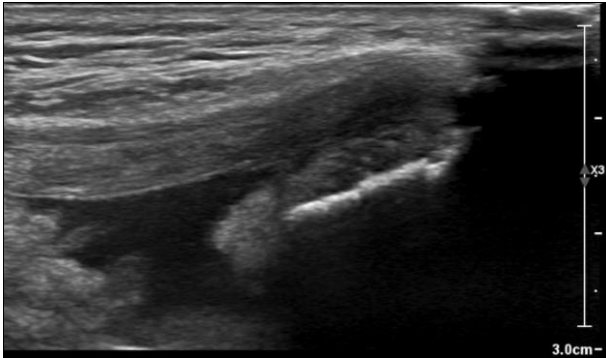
Ultrasound of the quadriceps tendon with the probe oriented longitudinally over the tendon. There is notable tearing and retracting of the underlying vastus musculature with intact tendon superiorly in the image.
